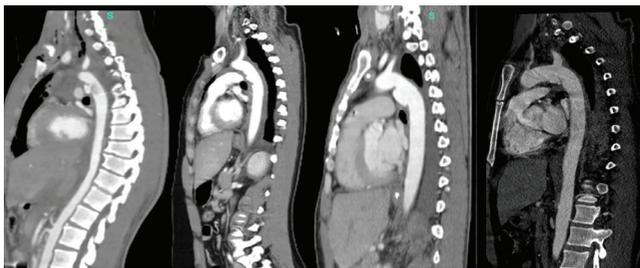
Sagittal CT angiography showing BTAI grade III in patients 1-4.
